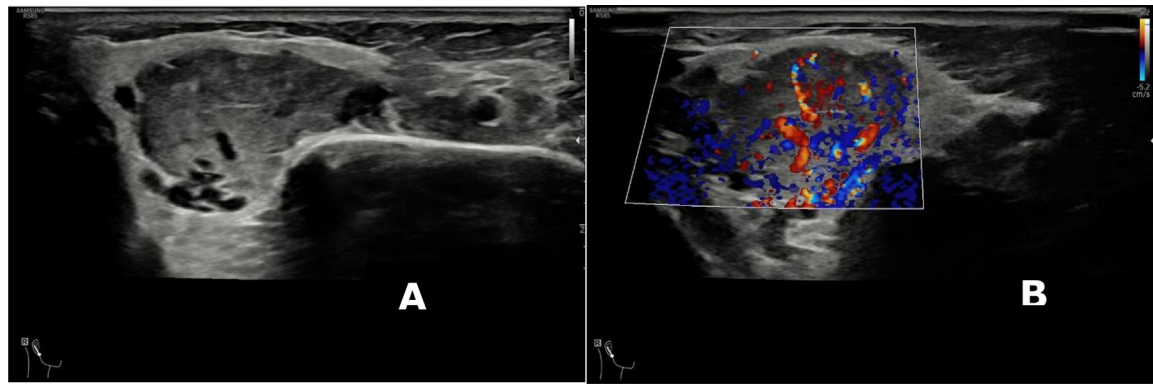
(A) Large formation occupying the right parotid gland. The lesion had polylobulated contours, a hypoechoic appearance compared to the small portion of the remaining parotid, relatively homogeneous content with the presence of fine hyperechoic septa and multiple and coarse vessels prominent in the context. (B) Multiple and coarse vessels prominent in the context and marked vascularization at the evaluation with color Doppler.
